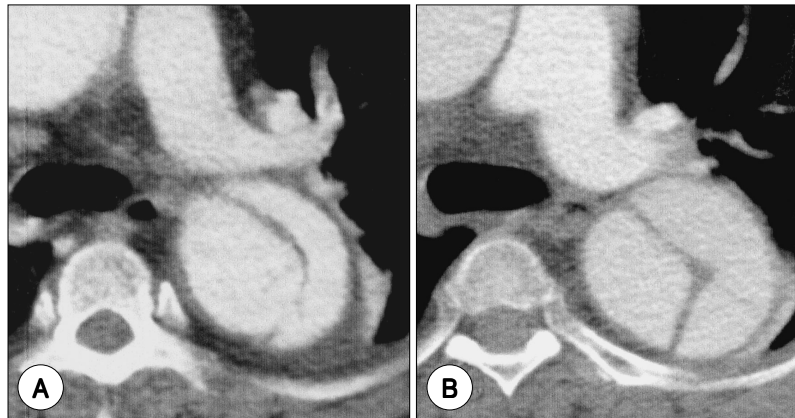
Morphologic change of aorta in classic aortic dissection after long term follow-up. A : CT angiography of a 61-year-old male at the time of diagnosis of acute aortic dissection. Aortic dissection in descending thoracic aorta at carina level are seen, B : at 21 months follow-up, false lumen increased from 6.6 cm² to 11.6 cm², and total outer aorta area increased from 21.7 cm² to 24.7 cm².
